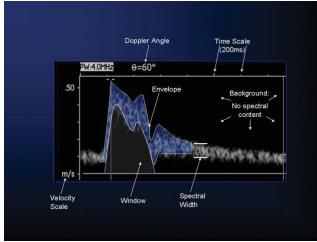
Arterial spectral Doppler waveform descriptors.
